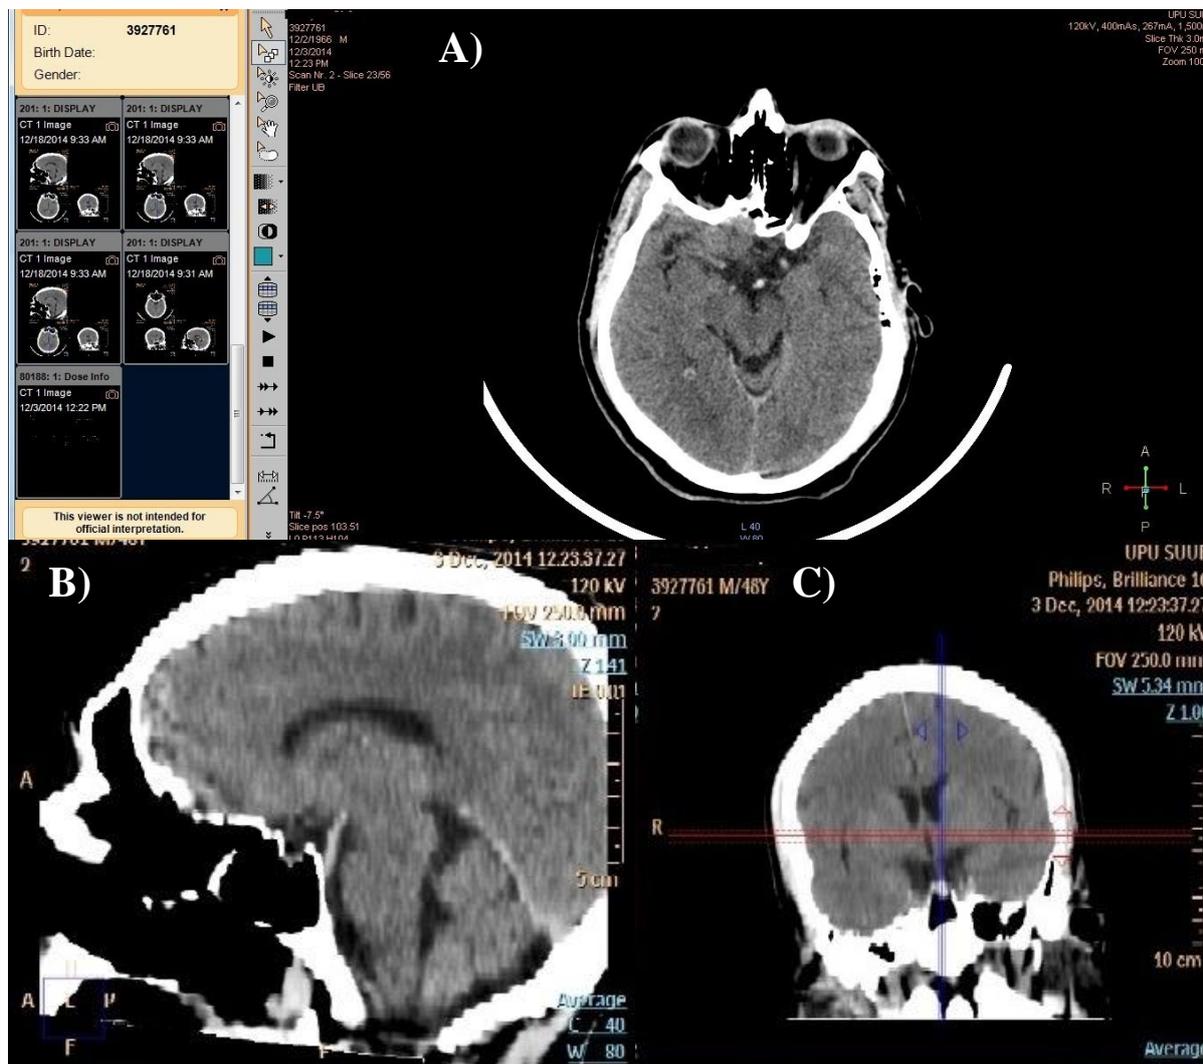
Native brain CT – A) Axial view, B) Sagittal view, C) Coronal view
